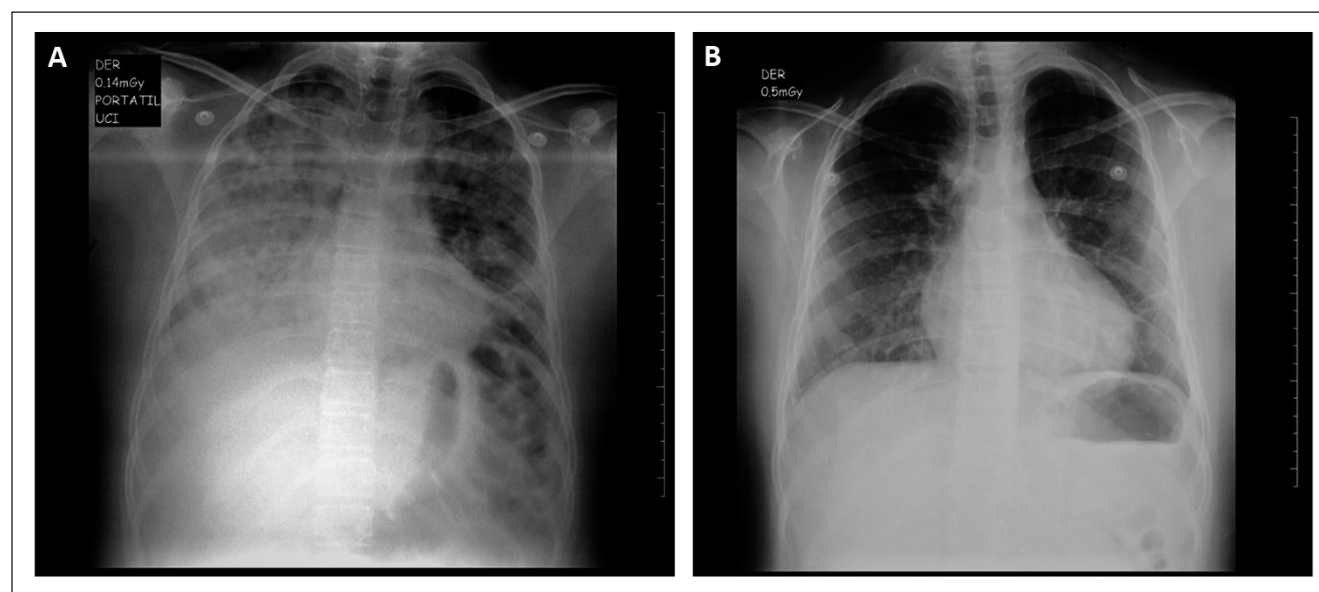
Case 6, image A shows the admission radiograph showing homogeneous opacities in the right hemithorax with partial effacement of the right phrenic cost angle and pseudonodular infiltrates in both lung fields. Image B shows the control radiograph taken at 24 hours, which shows improvement in pulmonary opacities with persistence of these at the bibasal level.
